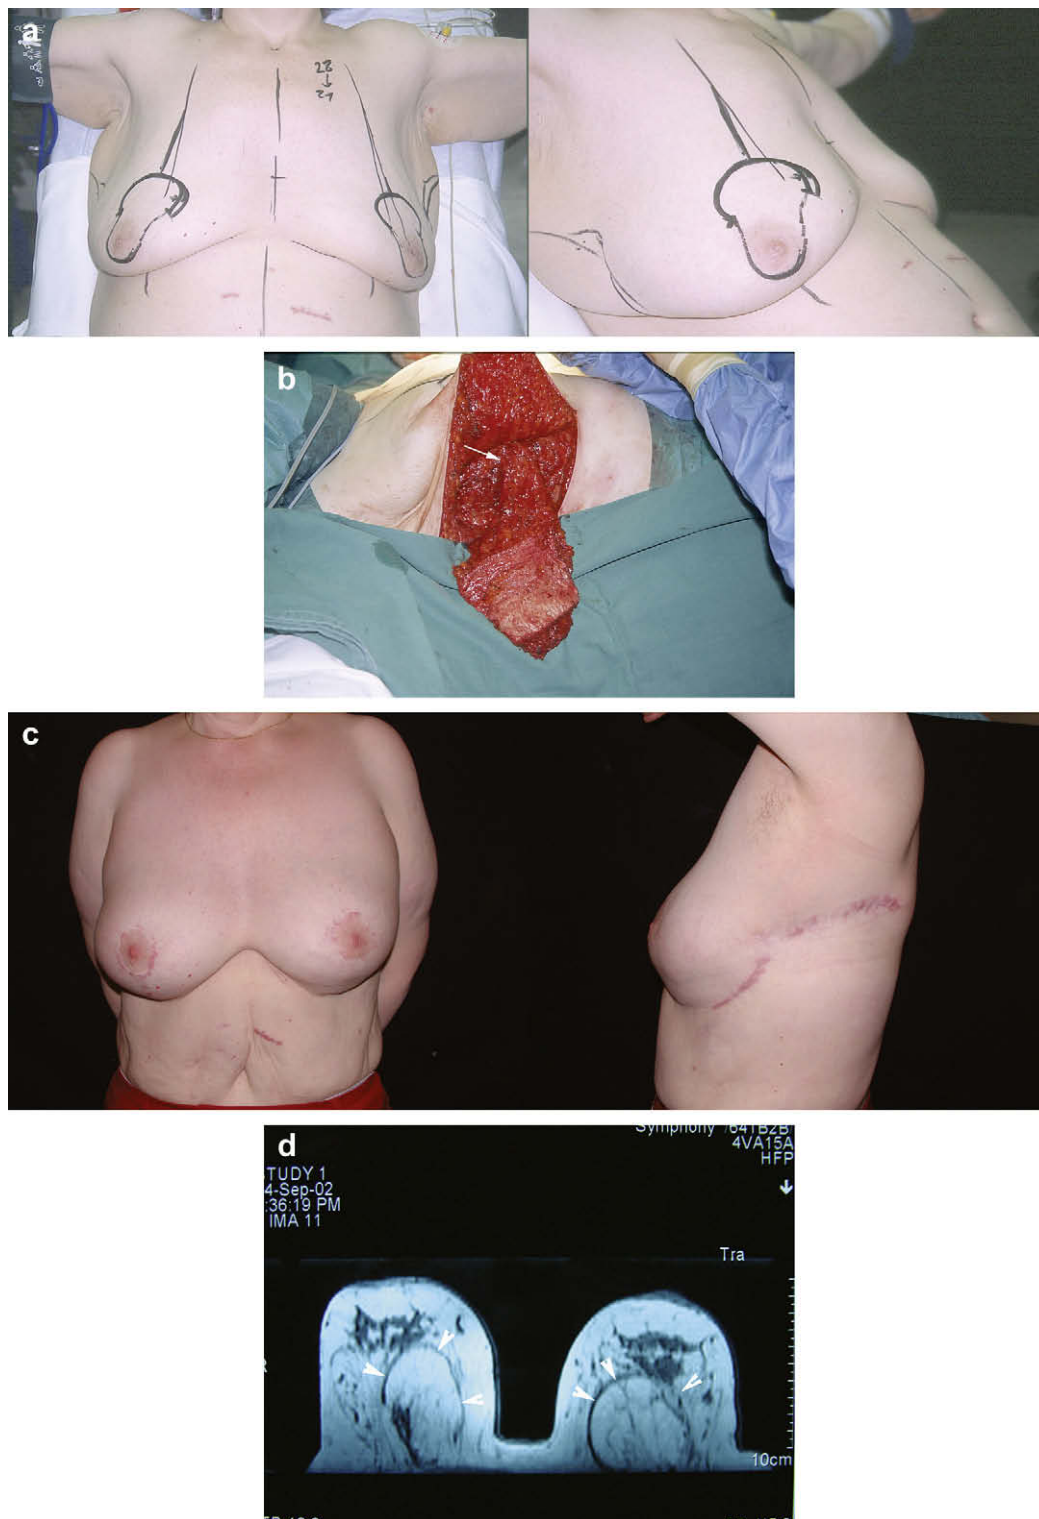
A simultaneous inverted-T mastopexy with pedicled LICAP flap. a. The flap designed over the skin-fat excess at the lateral sides. b. The (LICAP) flap was completely de-epithelialized and based on one perforator. c. The result at 2 years postoperatively. d. Magnetic resonance image shows survival of the flap without any fat necrosis.
